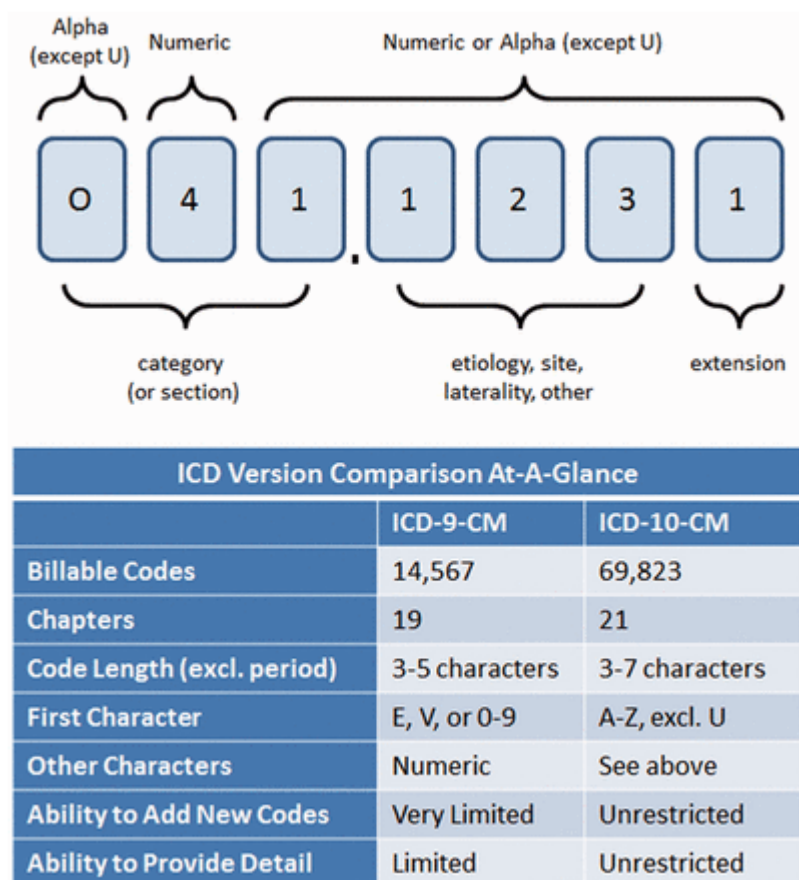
ICD-10-CM code character description and ICD version comparison. From “Leveraging the NLM Map From SNOMED CT to ICD-10-CM to Facilitate Adoption of ICD-10-CM” by F. P. Cartagena, M. Schaeffer, D. Rifai, V. Doroshenko, and H. S. Goldberg, 2015, *Journal of the American Medical Informatics Association*, Advance online publication, p. 4. Reprinted with permission (see Appendix B).
